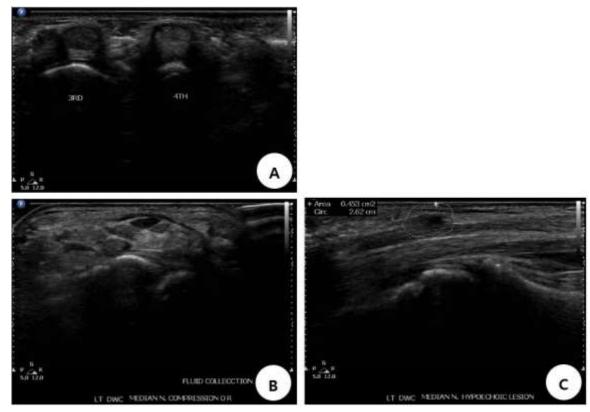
Ultrasonography (A) No abnormal finding was noted in the palm of left hand including a 3rd web space. (B) The left median nerve was compressed at the distal wrist crease level. (C) A swelling of the left median nerve and fluid collection around it were noted at the distal wrist crease level.
